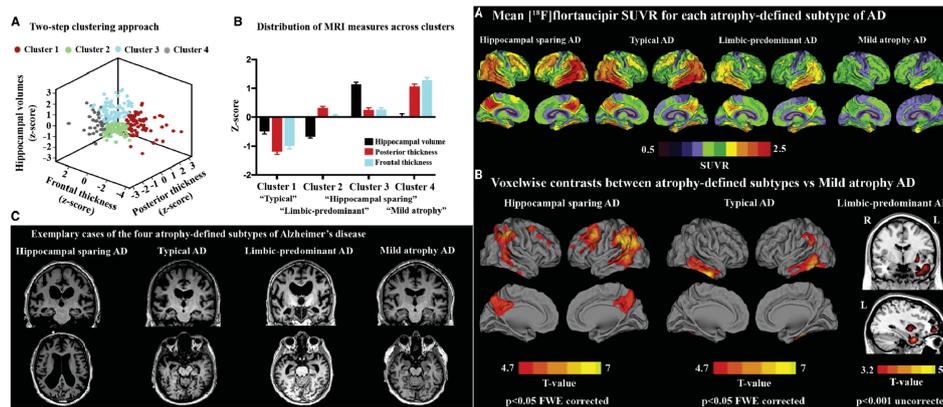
Tau-PET patterns in semi-supervised atrophy-based AD subtypes, adapted from (Ossenkoppele et al., 2019). (LEFT) Individuals were clustered based on MRI-derived atrophy in three ROIs, resulting in four subtypes consistent with previous literature. (RIGHT) Flortaucipir signal binding patterns for each subtype.
